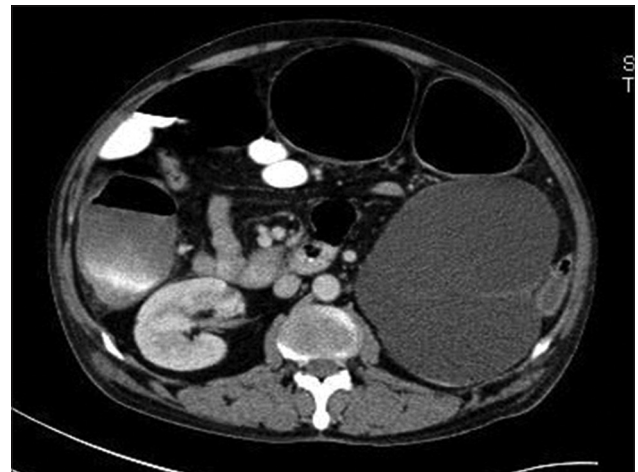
Axial section of Contrast-Enhanced Computed Tomography abdomen shows gross hydronephrosis of the left kidney with thinning of renal parenchyma
